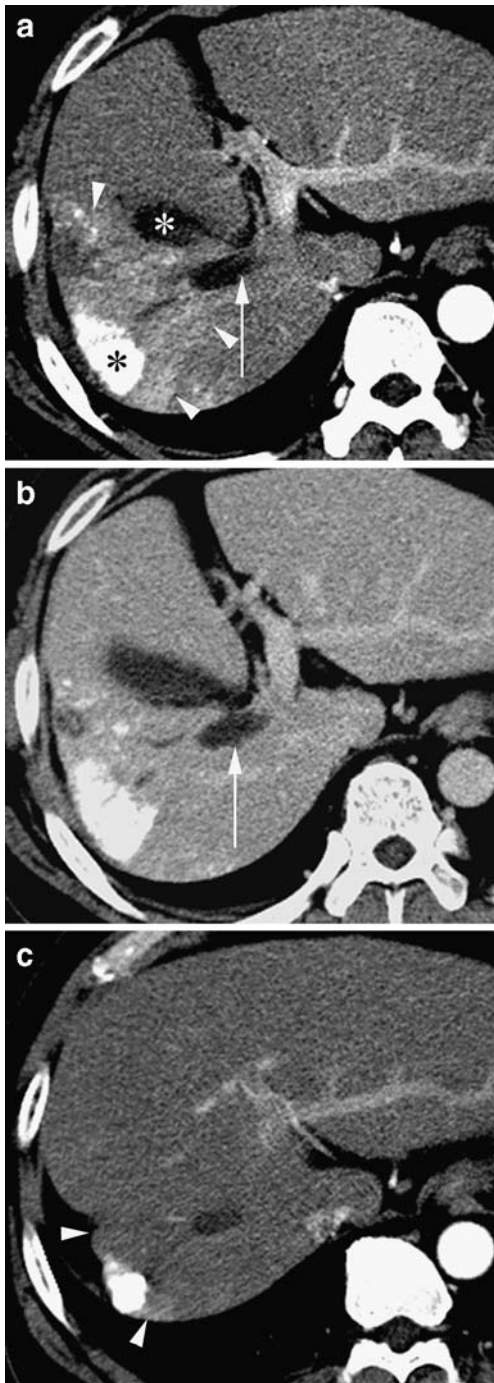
A 50-year-old man with a single hepatocellular carcinoma treated by a single session TACE showing iatrogenic portal tract injury consisting of biloma and portal vein obliteration in right lobe of the liver. a Arterial phase dynamic CT obtained 3 weeks after TACE shows a wedge-shaped increased attenuation area (arrowheads) surrounding the tumor with iodized-oil accumulation (black asterisk) associated with the linear non-enhancing low density of portal tract injury (arrow). White asterisk=gallbladder. b Portal phase dynamic CT of the same level as a shows obliteration of right portal vein related to the biloma along the portal tract (arrow). c Five-month follow-up arterial phase dynamic CT shows that the THAD disappeared with marked parenchymal atrophy of right lobe of the liver (arrowheads)
